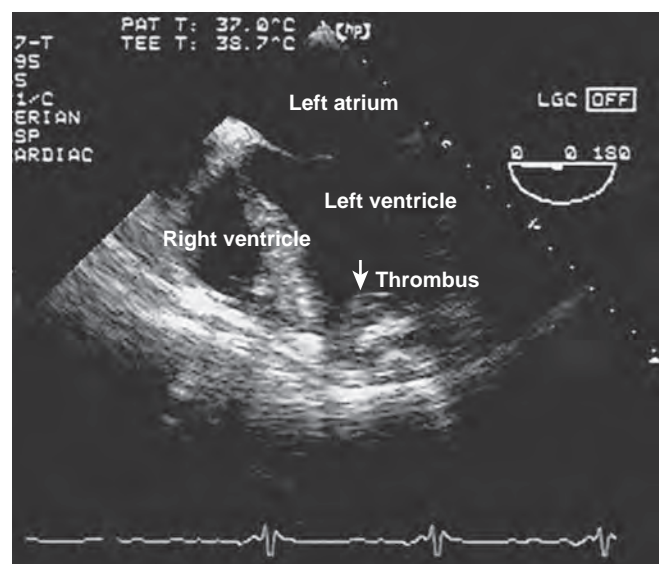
Transesophageal echocardiographic image of laminated intraventricular thrombus in the native left ventricular apex. If intracavitary thrombus is found, great caution is warranted during dissection before cardiopulmonary bypass to avoid systemic embolization.
